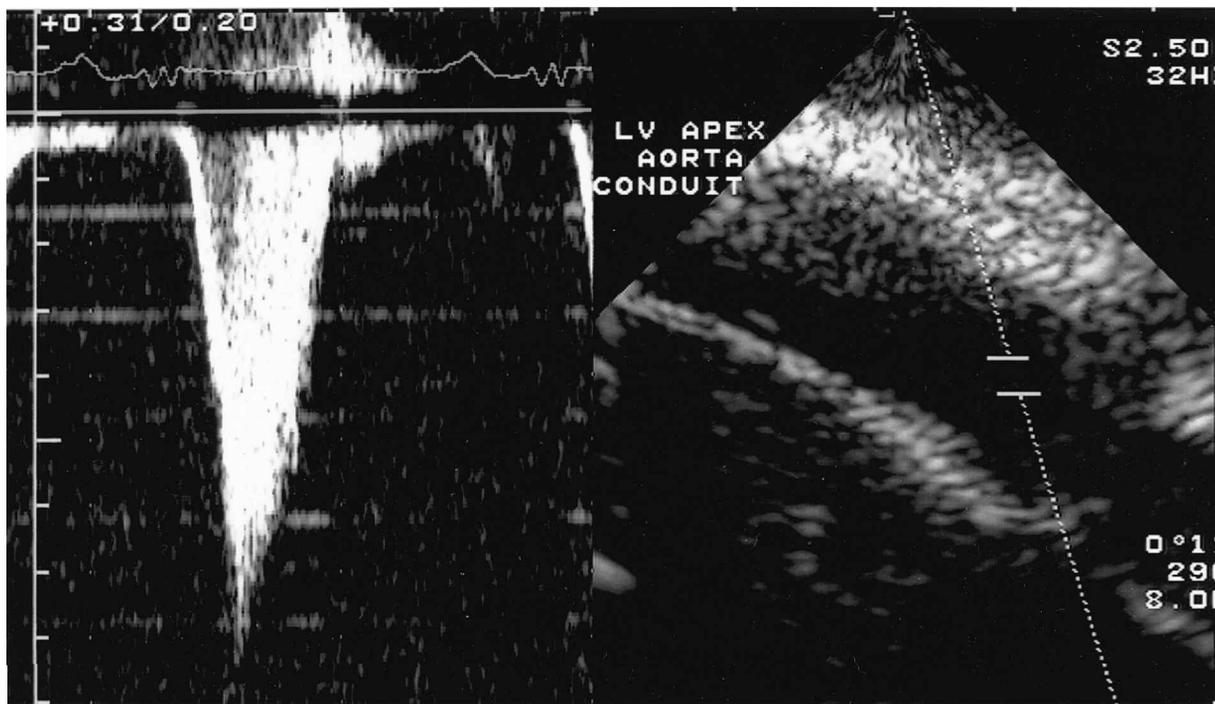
TTE image with pulsed-wave Doppler demonstrates laminar conduit flow just distal to the site of the Hancock bioprosthetic valve.
